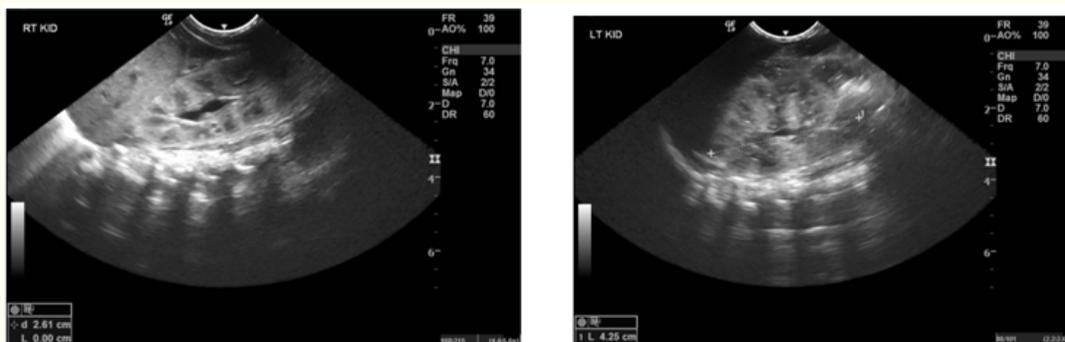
Renal ultrasonographic at age of 1 month: bilateral grade I hydronephrosis.
